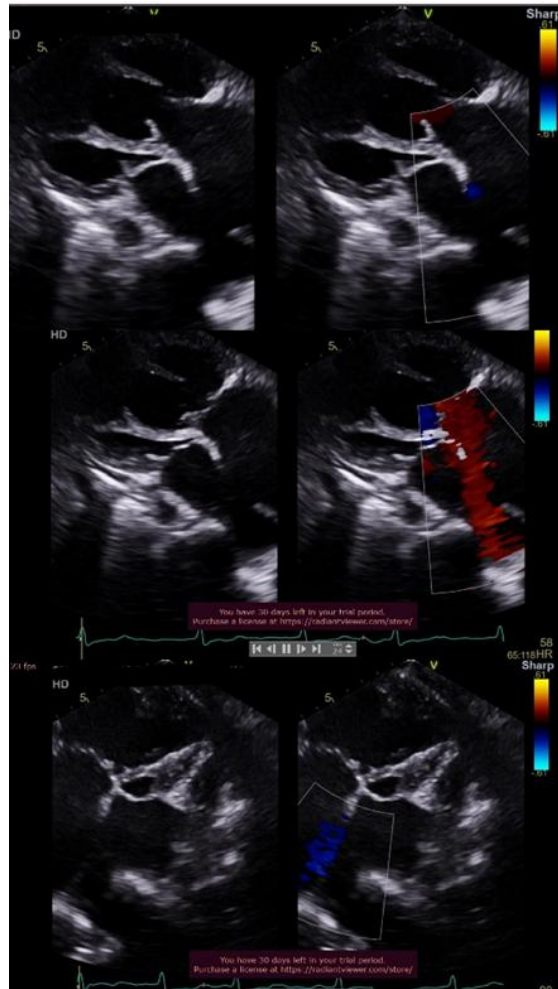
Echocardiogram showing ASD with bidirectional shunt
